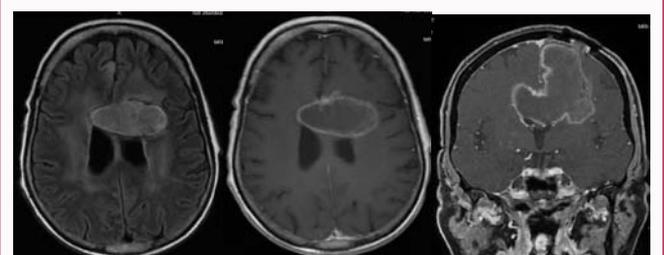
MRI dated 2/11/2020 demonstrating 5.6 cm × 3.5 cm × 6.0 cm (transverse × anteroposterior × craniocaudal) lesion. Sequences are (from left-to-right) axial T2 FLAIR, axial T1 post-contrast, coronal T1 post-contrast.
